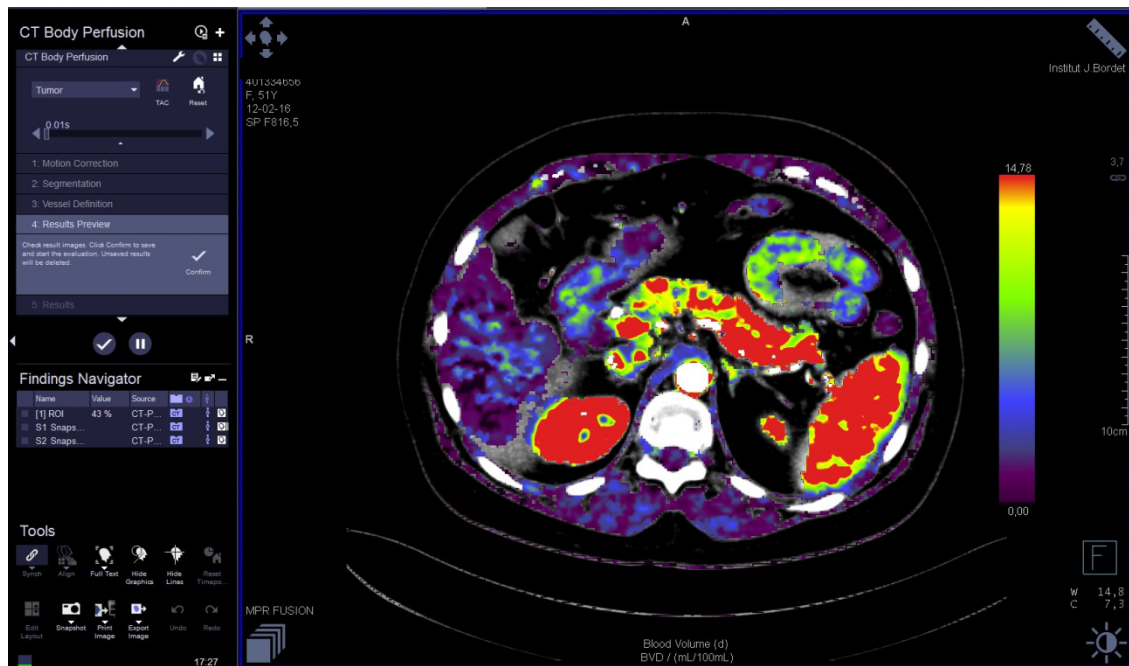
(A). Perfusion CT image processing.
